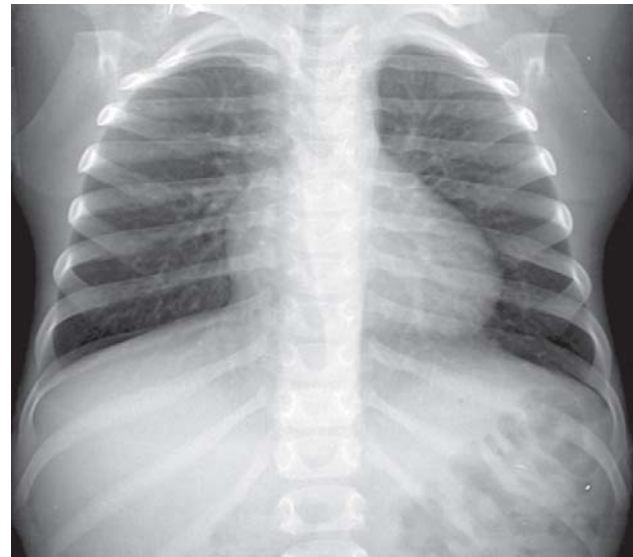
Preoperative X-Ray of thorax with cardiomegalia by the enlargement of the right chambers
